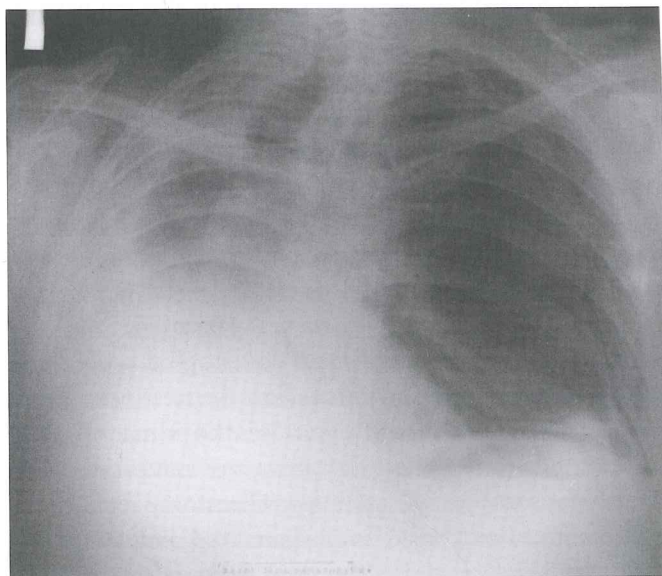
Chest X-ray showing persistent pneumothorax after tube drainage.
